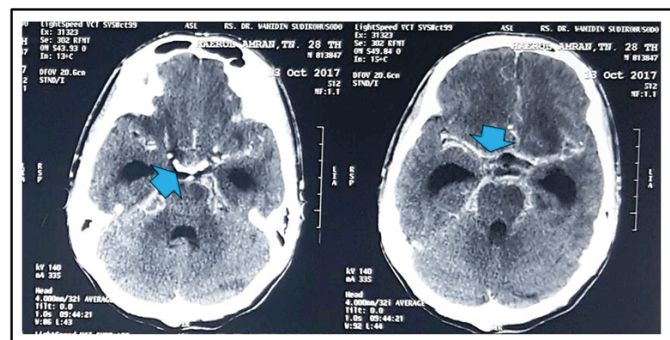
Contrast axial section of Head CT Scan showed basal exudate enhancement corresponded to the accumulation of thick exudate in the basal cisterns (blue arrows).
